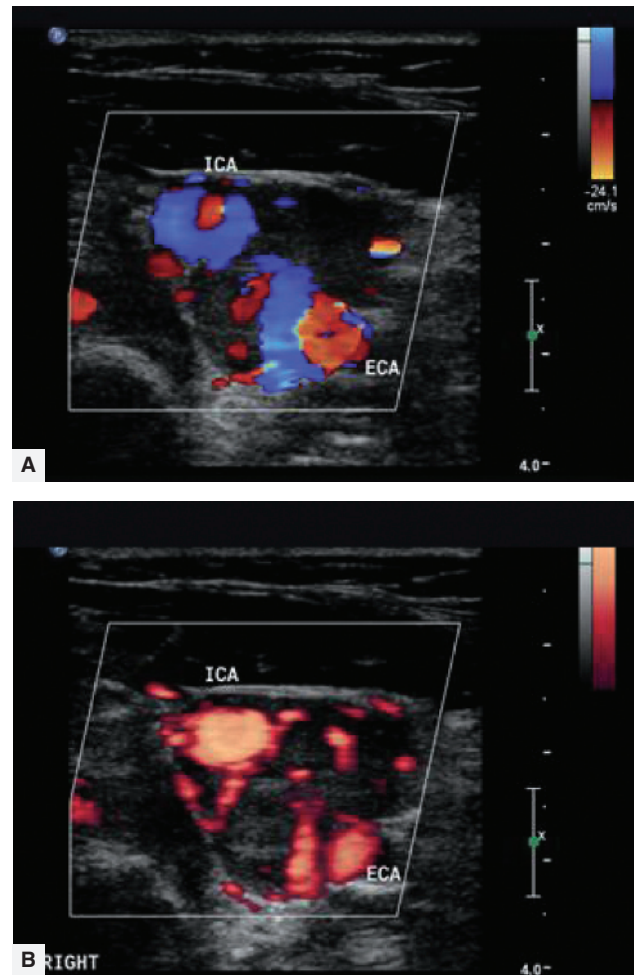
(A) Color and (B) power Doppler images of a carotid-body tumor. The tumor splays the carotid bifurcation, and the color flashes within the tumor reflect the highly vascular nature of these tumors.
